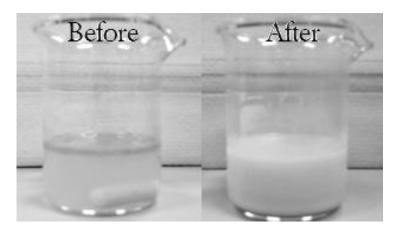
Emulsion mixture of chitosan solution and calendula infused oil: before ultrasonic crashing (left); after ultrasonic crashing (right)
